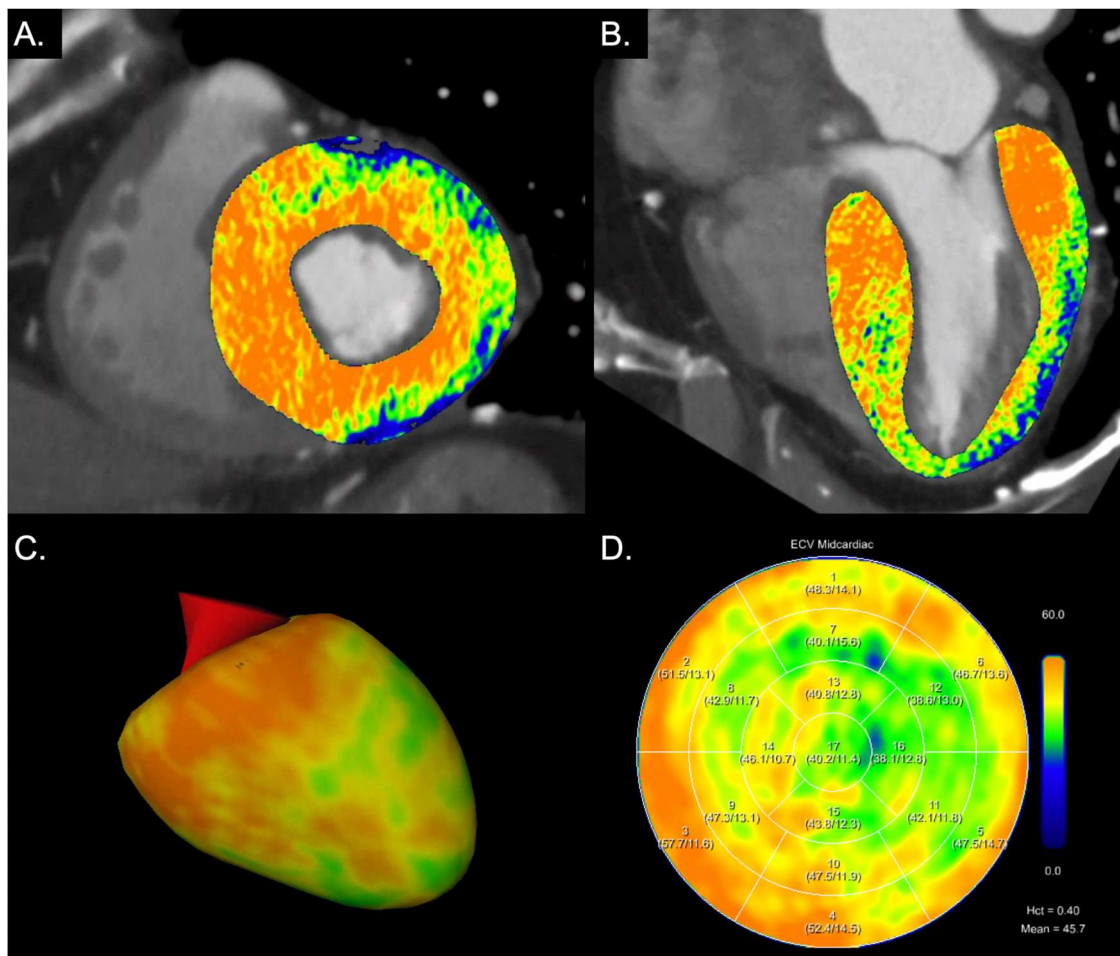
Myocardial extracellular volume (ECV) computation in an 84-year-old male patient with severe aortic stenosis. Images are displayed as short axis (A) and 2-chamber views (B) of extracellular maps calculated from the late enhancement scan superimposed on coronary CT angiography images, 3D model of the left ventricle (C), and ECV polar map according to the 17-segment model of the American Heart Association (D). Blood hematocrit was 0.404 L/L resulting in a mean midmyocardial ECV of 45.7%; synthetic hematocrit was 0.382 L/L resulting in a mean midmyocardial ECV of 47.2%. Myocardial ECV was elevated, while ECV values at the apex were lower (apical sparing), indicating cardiac amyloidosis. Hct, hematocrit
